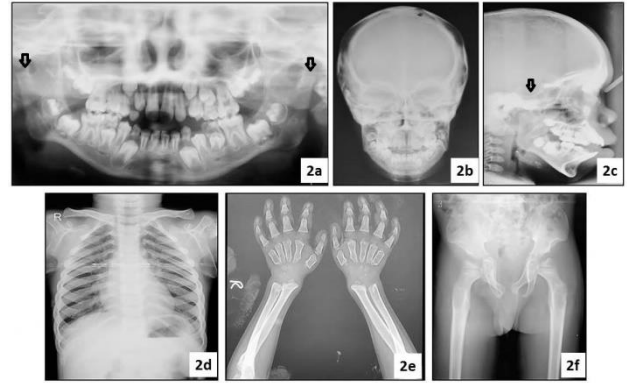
OPG shows hypoplastic mandibular condyles (arrow) and delayed tooth eruption (2a), PA skull did not show thickening of the skull vault (2b), lateral ceph shows J-shaped sella turcica (arrow) (2c), chest radiograph shows abnormal shaped ribs (oar shape) (2d), hand-wrist radiograph shows bullet shaped metacarpals (2e), and pelvic radiograph shows flared iliac wings and long and narrow femoral neck (2f).
